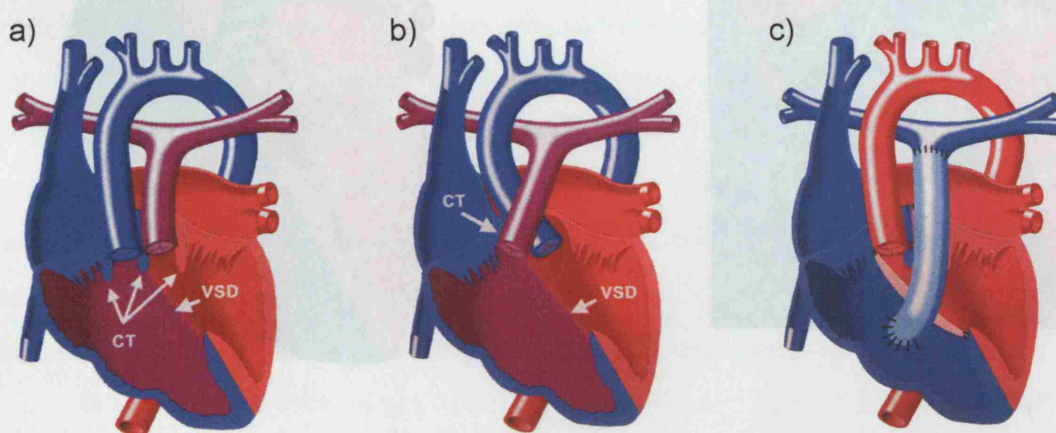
Double outlet right ventricle with a) transposed great arteries and b) normal orientation of the great vessels (CT – conal tissue). c) Rastelli procedure result with a valved conduit (light blue) and a VSD patch (pink).
